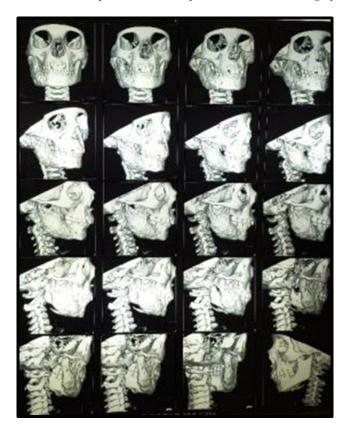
CT face showing mixed lytic – sclerotic area with sun ray spiculation and periosteal reaction, Adjacent masticator space shows soft tissue thickening and swelling, left half of mandible is normal in outline. Giving impression of osteogenic sarcoma
